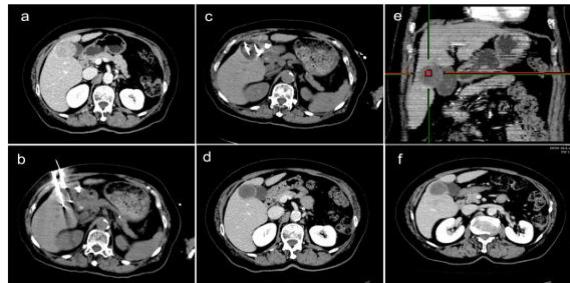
CT-guided percutaneous cryoablation of the liver demonstrating an HCC adjacent to the gallbladder. Baseline CT identifies the lesion (a), followed by CT-guided cryoprobe placement (b–c). Intraprocedural CT confirms adequate ice-ball coverage. Post-ablation imaging (d–e) shows a well-defined necrotic zone without gallbladder injury. Follow-up CT (f) demonstrates a non-enhancing ablation cavity, indicating successful tumor eradication.
